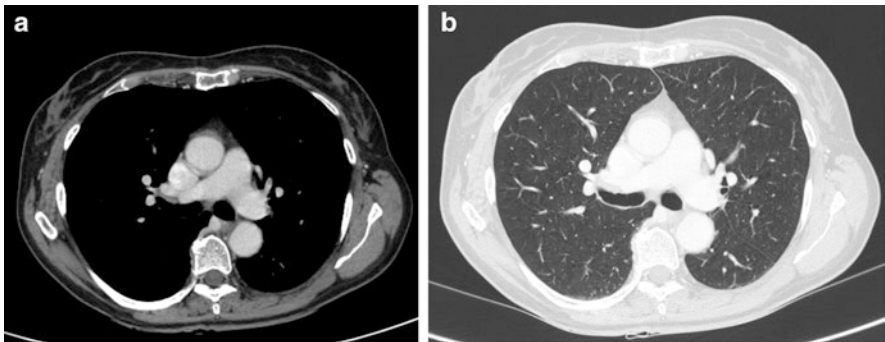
These pictures show the same slice of the chest CT examination of a patient, reconstructed with two different kernels: in (a) it has been used a smooth kernel (B20) in order to evaluate the mediastinum; in (b) has been used a sharp Kernel (B46f) which allows to better analyse the lungs
